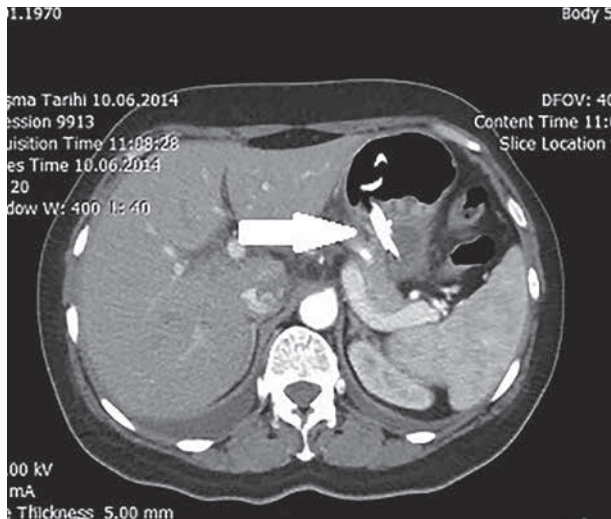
Seven days after the drainage. CT scan showed that the biloma significantly decreased in size.
